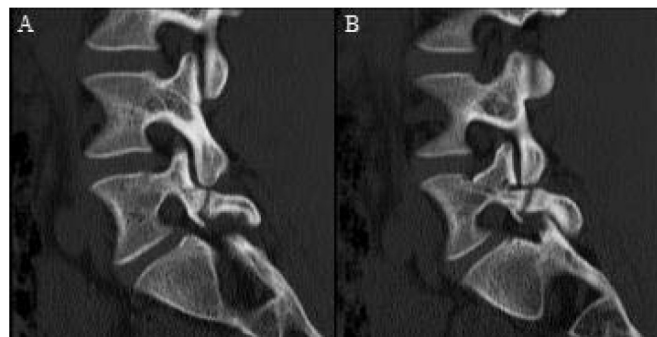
Pre-operative computed tomography scan (CT) demonstrating defects in the (A) right pars and (B) left pars.
